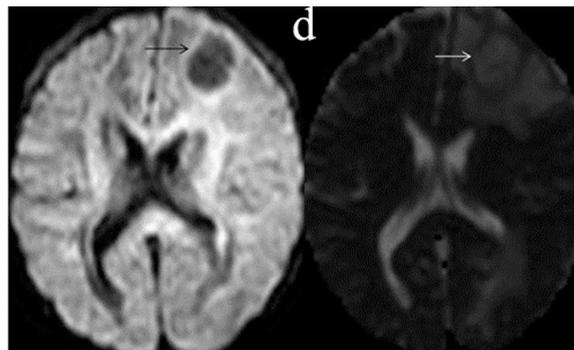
MRI brain revealing caseating granuloma
